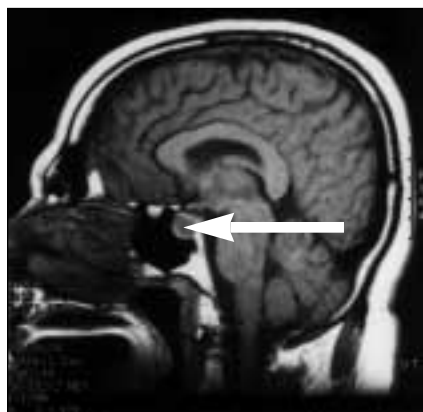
Midline sagittal section of precontrast MRI of head revealing pituitary macroadenoma (arrow).
